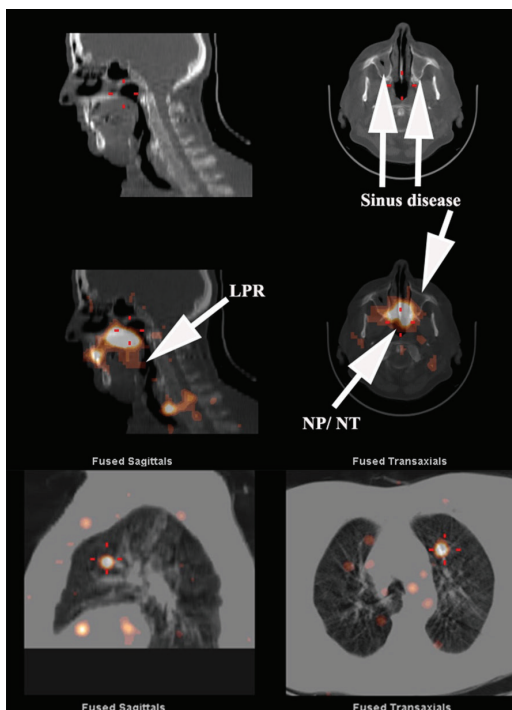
SPECT/CT image of head, neck and lungs. The CT image shows evidence of soft tissue thickening within the maxillary sinuses (arrows) consistent with sinus disease. The fused image in the middle panel demonstrates LPR, NP, NT and maxillary sinus contamination by refluxate. The lower panel shows aspirated refluxate within the lung tissue. Some misregistration is inevitable in the lungs due to respiratory motion and frequent coughing in many of these patients.
